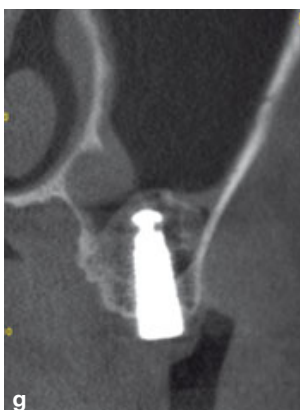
CBCT immediately following the insertion of the DIVA implant, demonstrating the creation of the selective sinus elevation.
